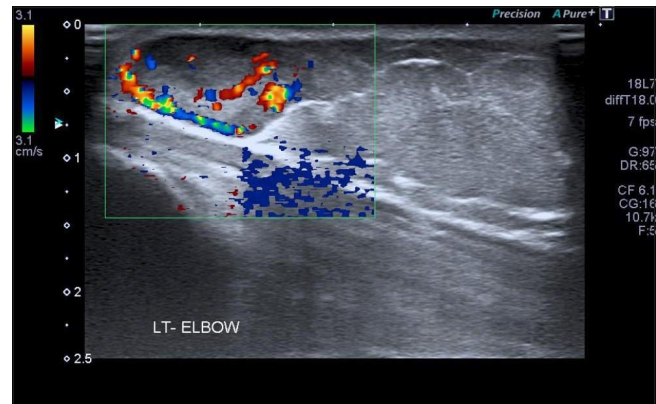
Doppler ultrasound image of the area of maximal point tenderness showing a well circumscribed subcutaneous lesion measuring 14x12x7mm with increased vascularity
